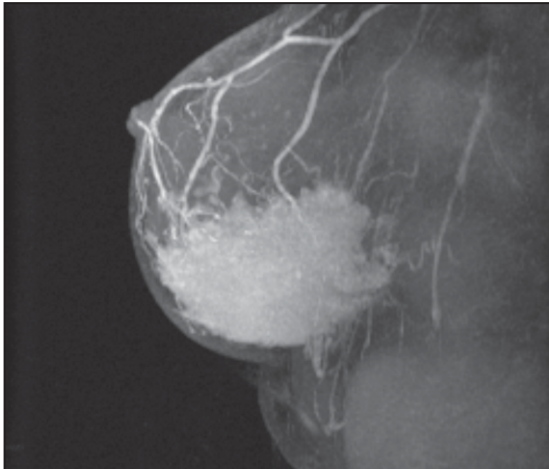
MRI mammography of patient with nipple discharge
